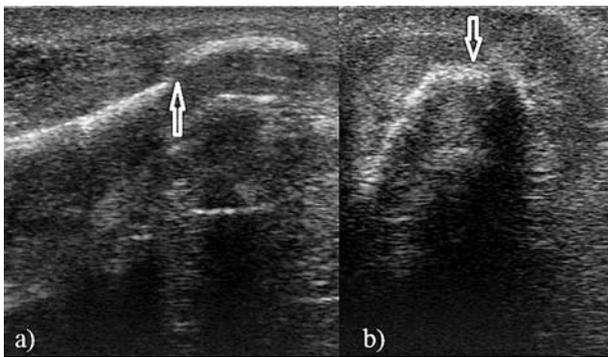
a) Axial ultrasonogram of dorsum shows intact cortical margin (arrow). B) Longitudinal ultrasonogram shows intact cortical margin as an echogenic line (arrows).
